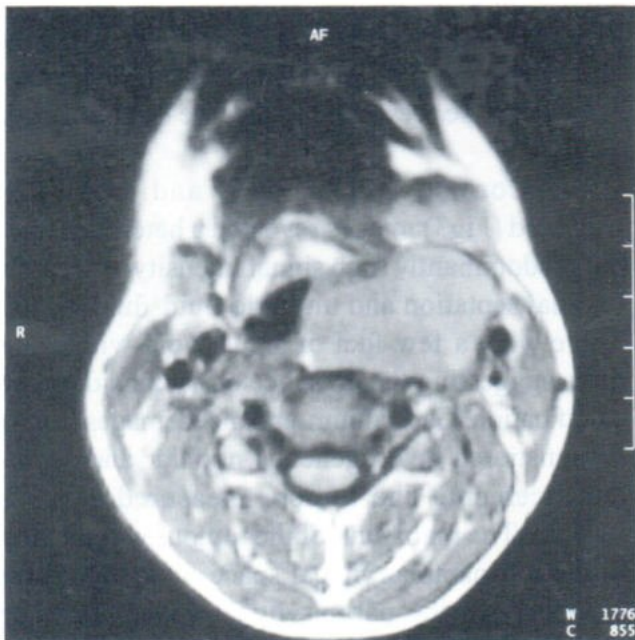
T1-weighted spin-echo axial image shows a well-defined lobulated mass with intermediate signal intensity. On the lateral aspect the mass demonstrated higher signal intensity suggesting the presence of haemorrhage.
